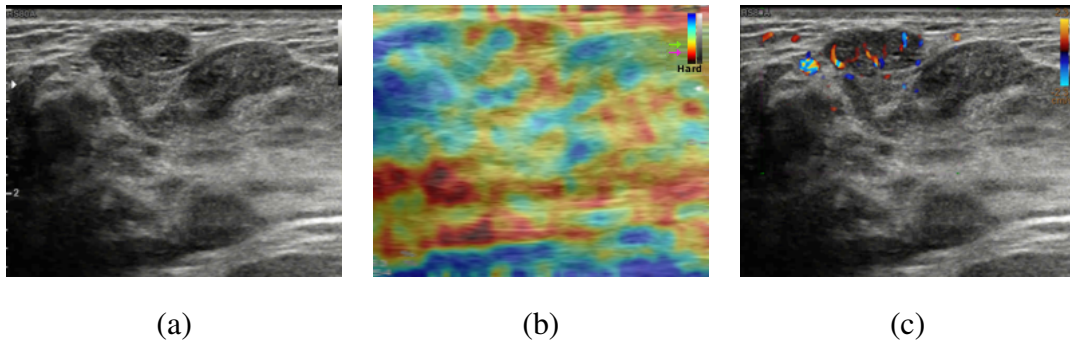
US images in a patient at Thammasat university hospital show high suspicious of malignant mass. (a) Conventional US shows an irregular hypoechoic mass. (b) Elastography shows the entire mass as red and dark red. (c) Power Doppler shows increased vascularity.
